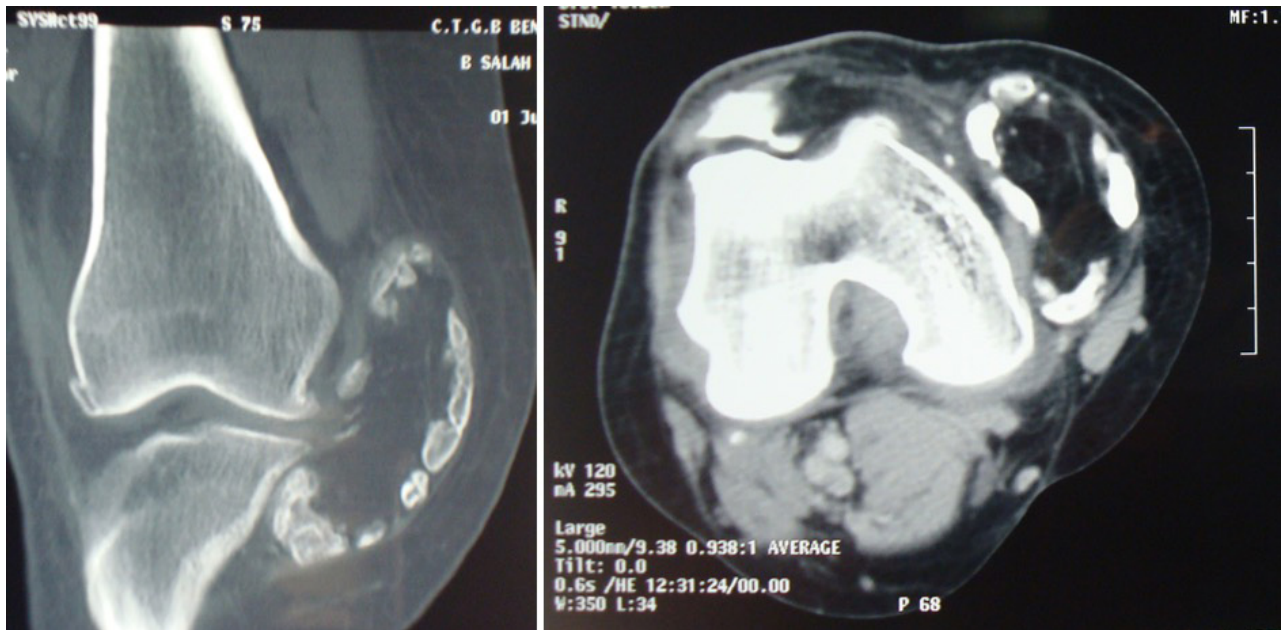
CT scan of the knee: juxta-articular heterogeneous mass of fatty density containing peripheral calcification ranges.
